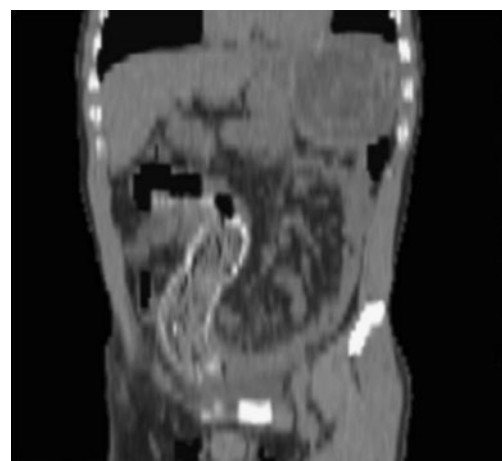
Contrast-enhanced computed tomography showing two foreign bodies located both ileum and spleen
